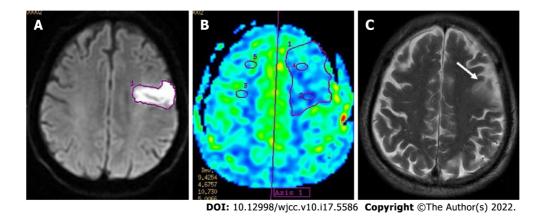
A 67-year-old male patient was admitted to the hospital due to dizziness, vomiting, and limb dysfunction for 12 h. Magnetic resonance imaging examination was performed within 4 h after admission, and the patient was diagnosed with acute cerebral infarction in the left frontal lobe. A: The diffusion-weighted imaging image and the focal area of cerebral infarction showing high signal performance; B: The color map of cerebral perfusion, showing significant hypoperfusion in the infarct lesion area; C: T2-weighted imaging, with the infarct area indicated by the white arrow showing high signal intensity (Arrow).
